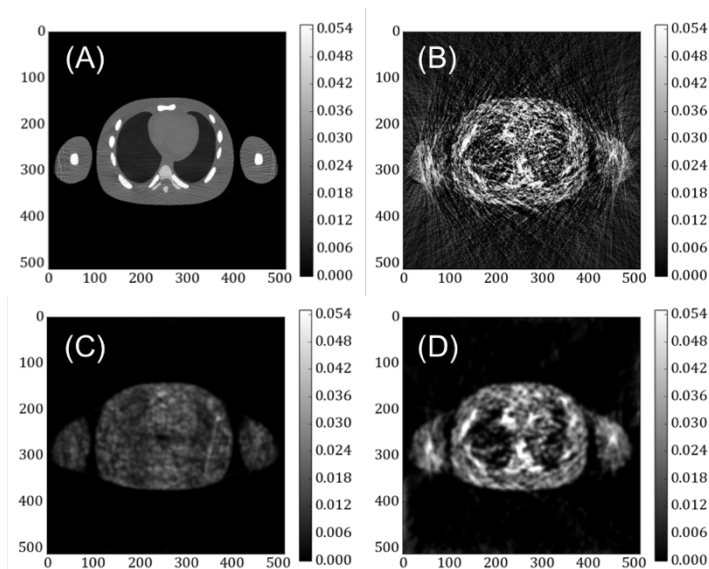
Comparison of reconstructed 0.5 mAs NCAT CT images
